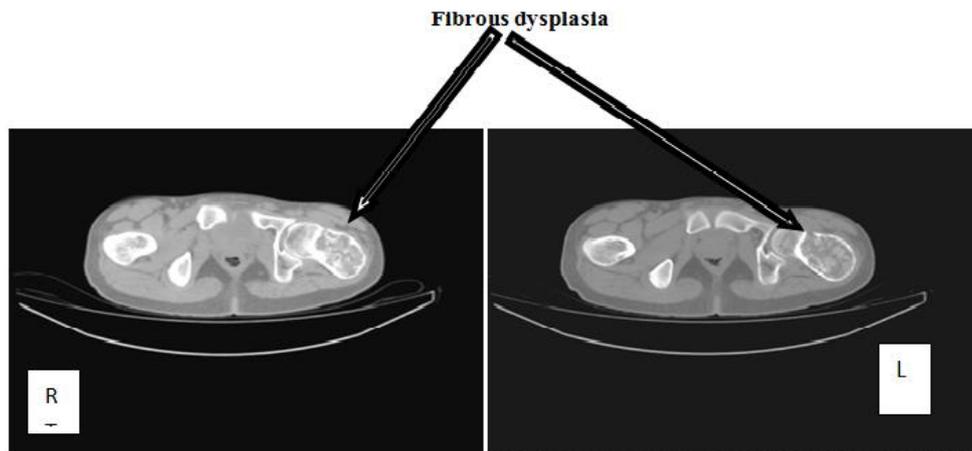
Two axial CT images of the upper left upper femur with different CT numbers (Dual window) show fibrous dysplasia (arrows).
